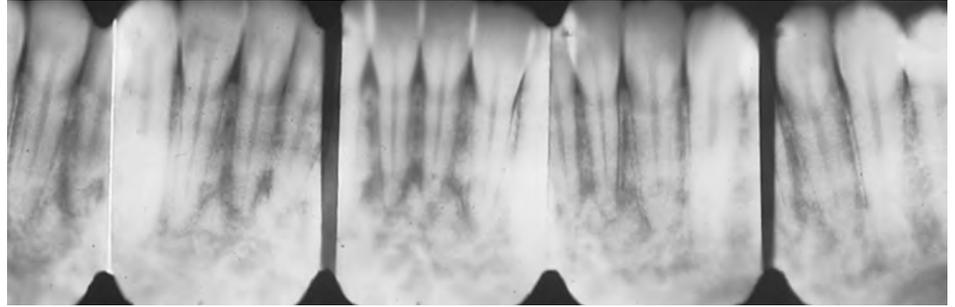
Periapical radiographs showing mixed radiolucent-radiopaque changes at the apices of vital mandibular anterior teeth.
